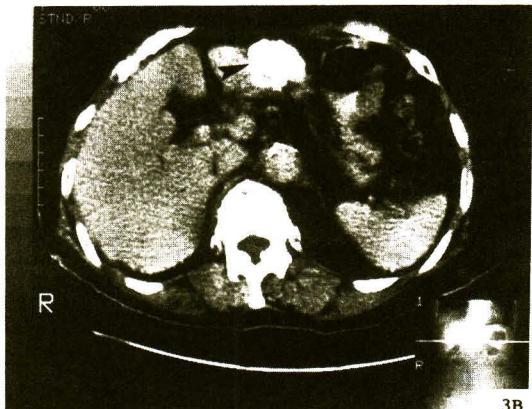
Lipiodol CT Scan of the same liver shown in Fig. 3 A shows homogenous accumulation of lipiodol.
